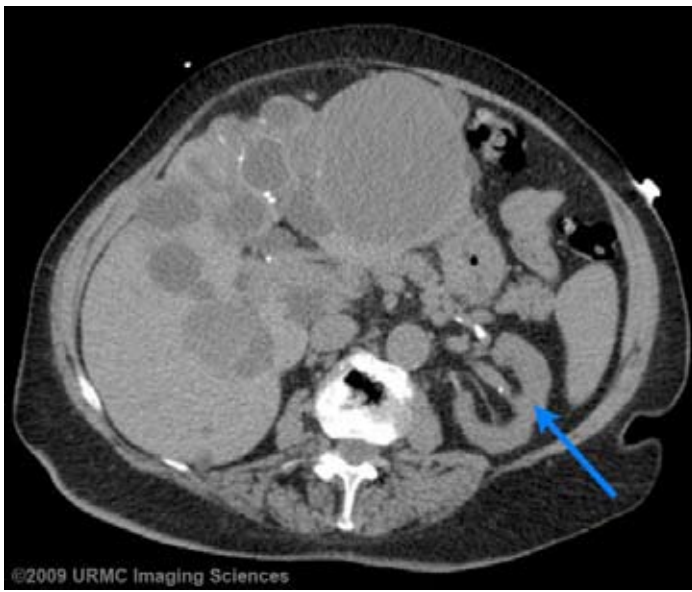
A CT image taken slightly more inferiorly again demonstrates innumerable hepatic cysts. Note that there is no involvement of the kidney (blue arrow).
